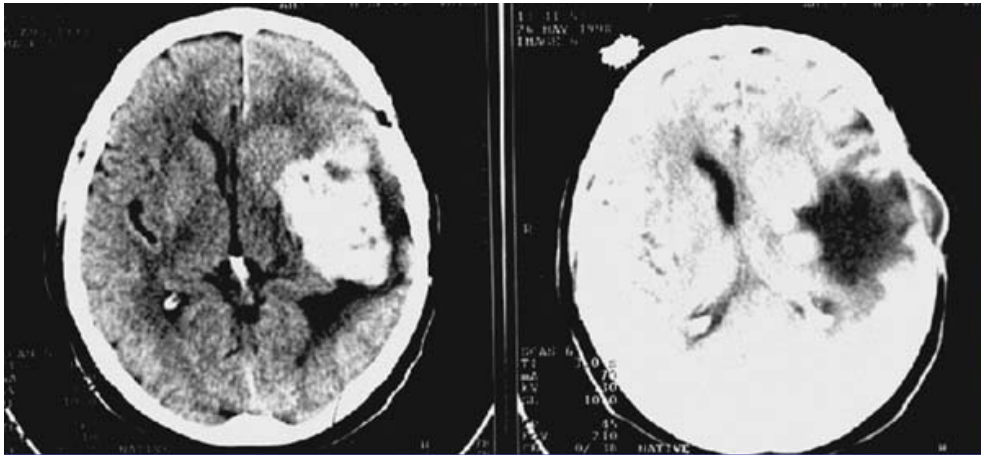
Pre and postoperative CT
